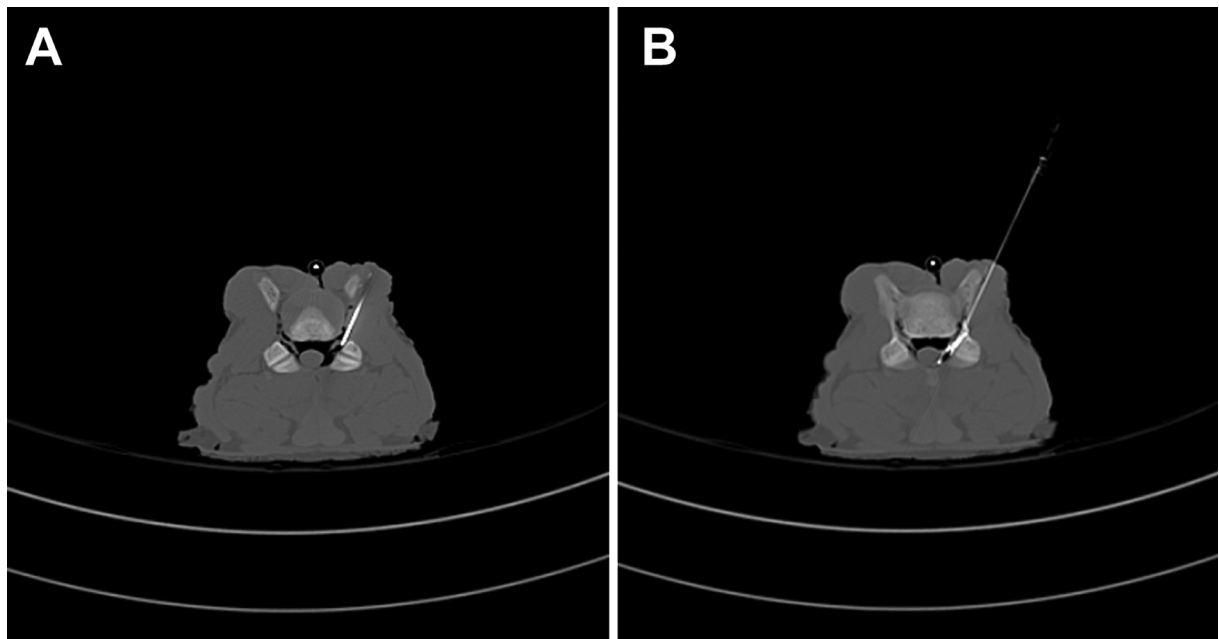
Post-puncture control CT images. A) Axial CT image to verify needle tip position. The needle tip is located in the posterior part of the neural foramen. B) Control image after contrast dye injection.
